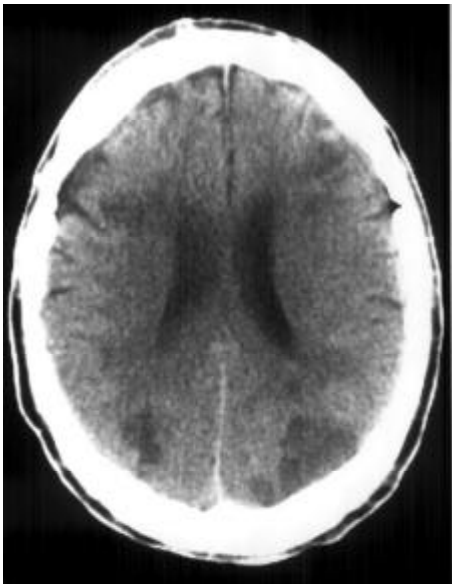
CT scan from a patient 2 weeks after a global hypoxic and ischaemic insult associated with severe head injury; bilateral boundary zone infarcts are seen anteriorly and posteriorly.
